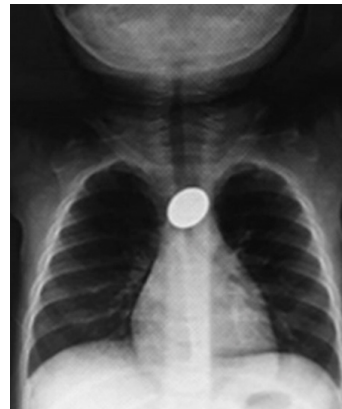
Foreign body in the 2nd narrowing of the esophagus in the chest X-ray.
